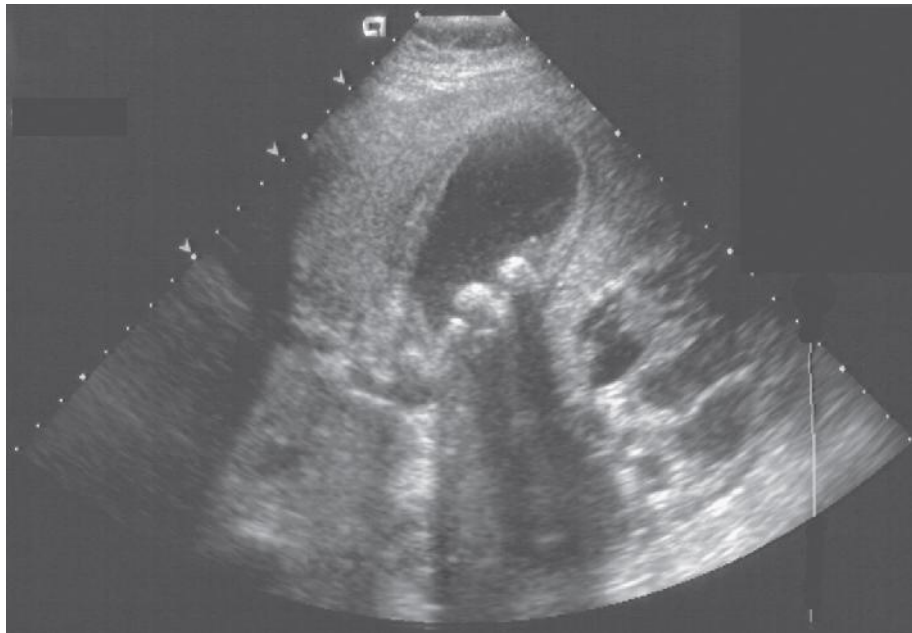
Ultrasound image showing multiple gallstones with thickened gallbladder
